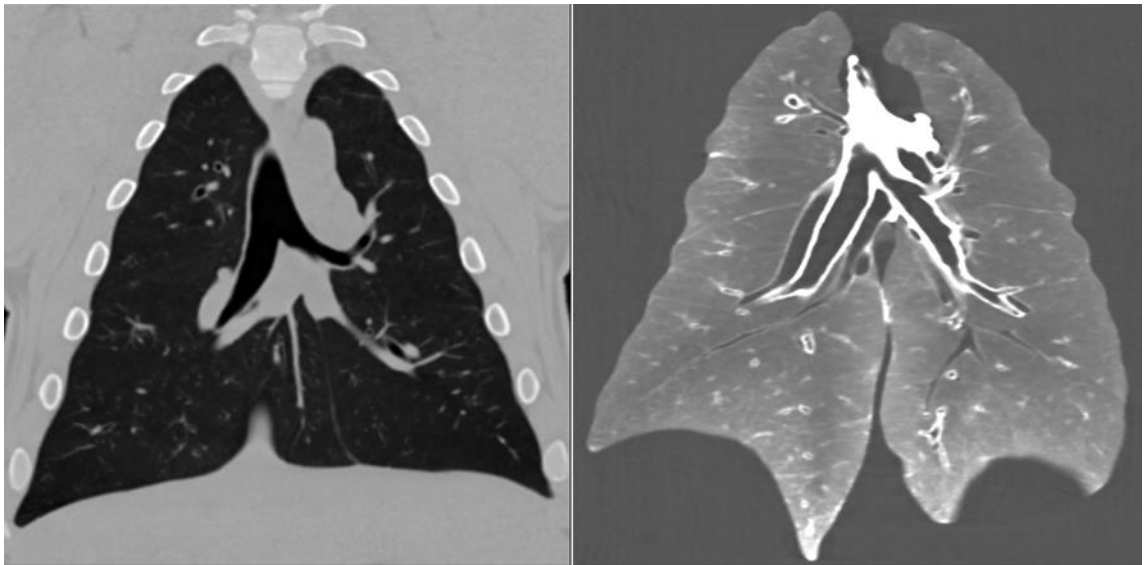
In-vivo and ex-vivo lung comparison. The left image shows the lungs from subject 40016 in-vivo and the right image shows the same lungs ex-vivo. The method of fixation via the vascular system causes blood to be removed from the vessels and hence no longer appears radio-opaque in post fixation CT data.
